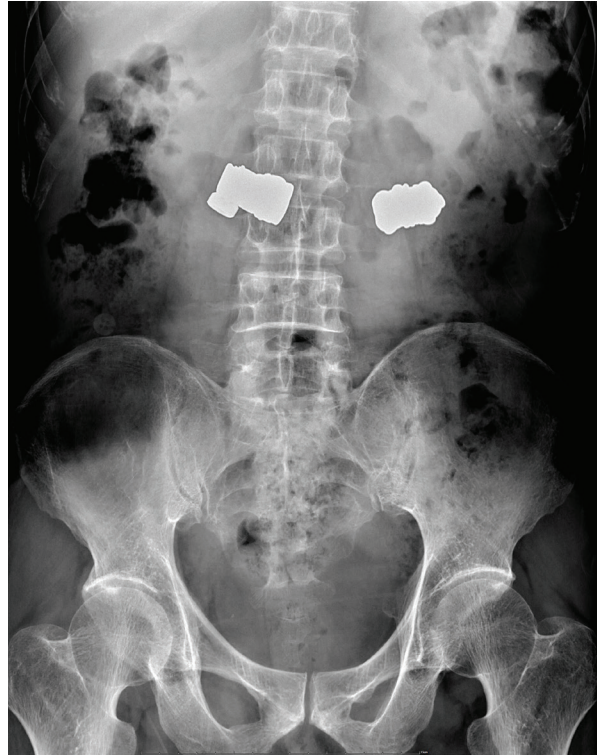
A kidney, ureter, and bladder X-ray film. Two metallic foreign bodies are found in the abdomen.
